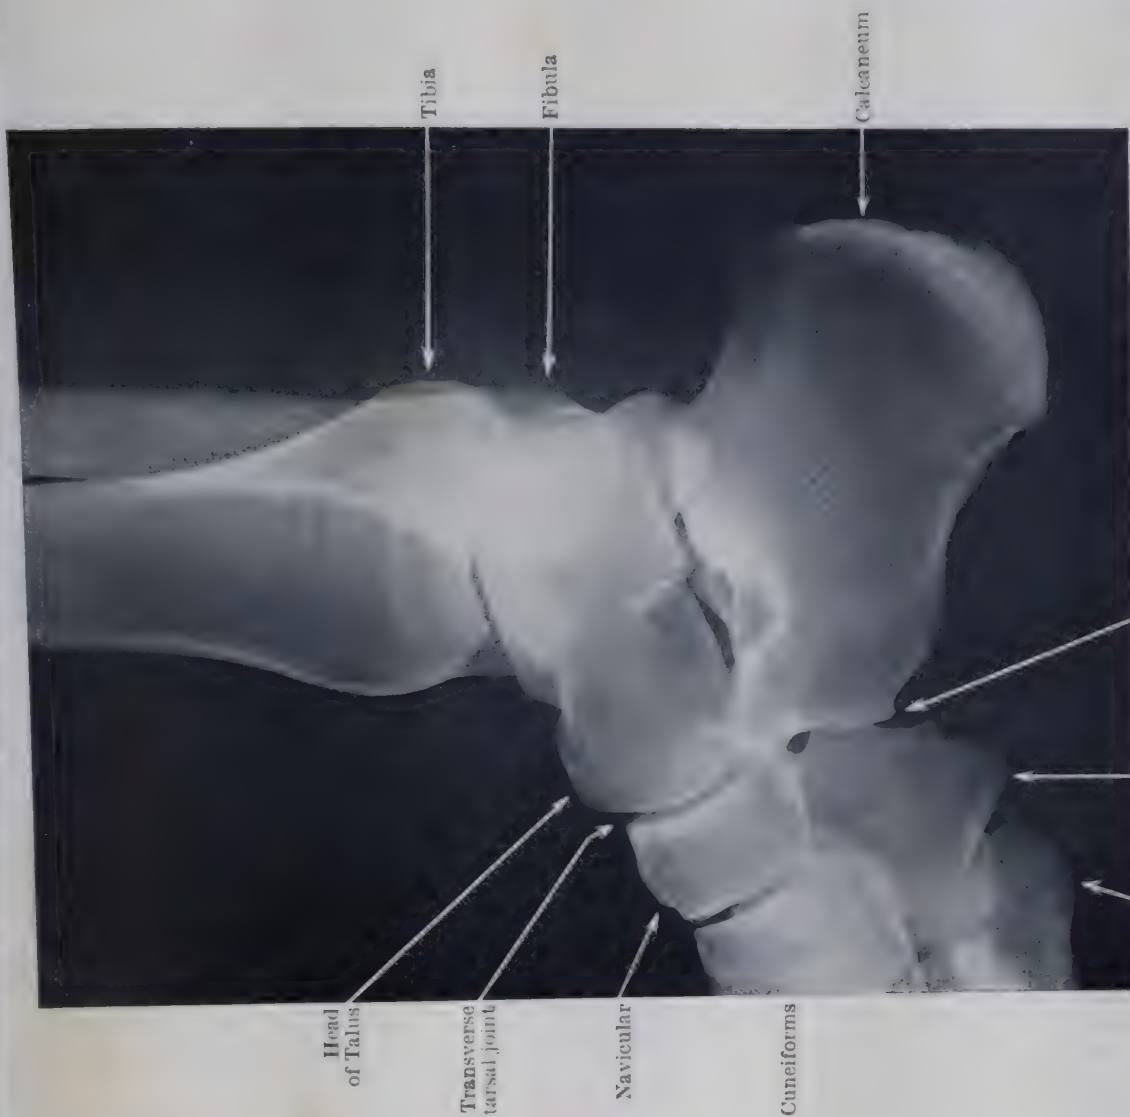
LATERAL RADIOGRAPH OF THE SAME ANKLE AND TARSI. (Dr. J. Duncan White.) Cf. Plate XXVII, p. 320, noting the change in the relation of the articular surfaces of Tibia and Talus during movements of the Ankle.
